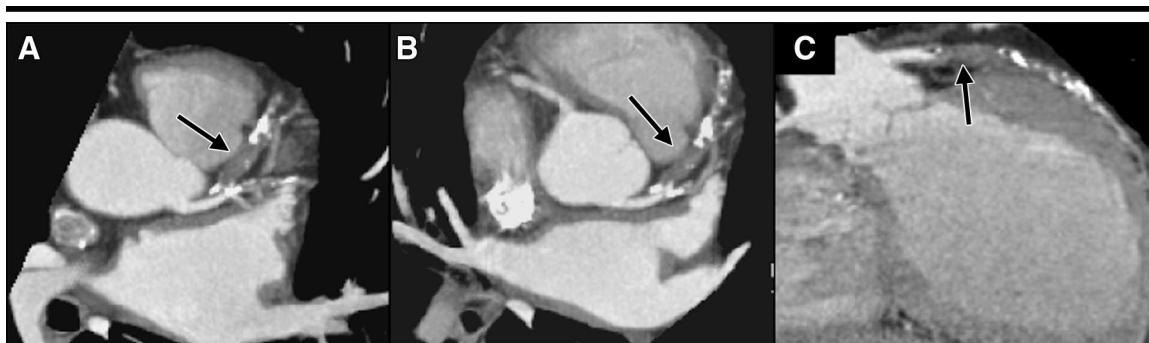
Thrombotic coronary occlusion at the site of positive remodeling at four-detector row CT. *A, B*, Oblique transverse thin maximum intensity projections and, *C*, craniocaudal curved multiplanar reconstruction demonstrate complete filling with thrombus of the ectatic lumen (arrows) of mildly calcified proximal LAD coronary artery.
